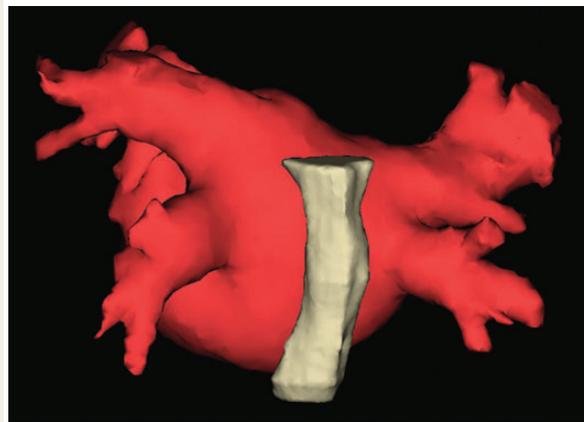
Three-dimensional reconstruction from CT scan (PA view) showing the LA and pulmonary veins (red) with the oesophagus (grey) lying in a midline position behind the atrium.
